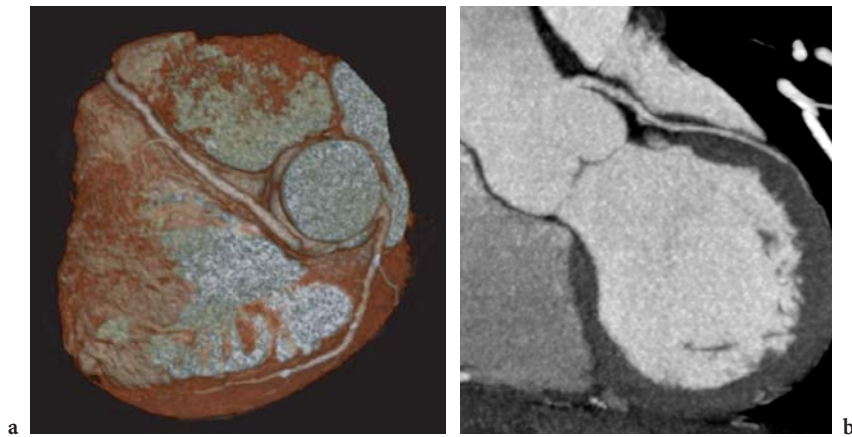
16-slice CT examination of a clockwise malrotation of the aortic trunk, leading to an interarterial course of the RCA. Note the additional ectopic origin of the LMA above the left sinus of Valsalva. Visualization with volume-rendering reconstruction (a) and thin-MIP reconstruction (b) showing the aberrant origin of the LMA
